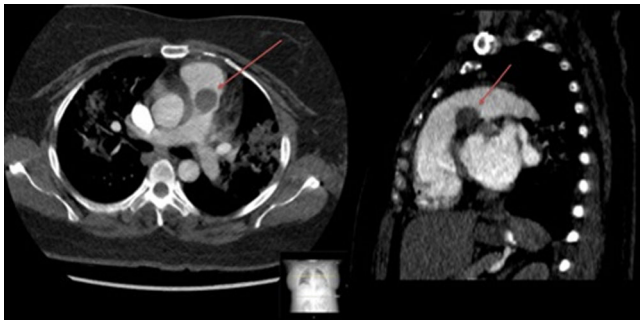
Axial and sagittal reconstructed images of a CT pulmonary angiography with incidentally noted eccentric, ovoid filling defect in the posterior aspect of the pulmonary trunk (red arrows). CT, computed tomography.
